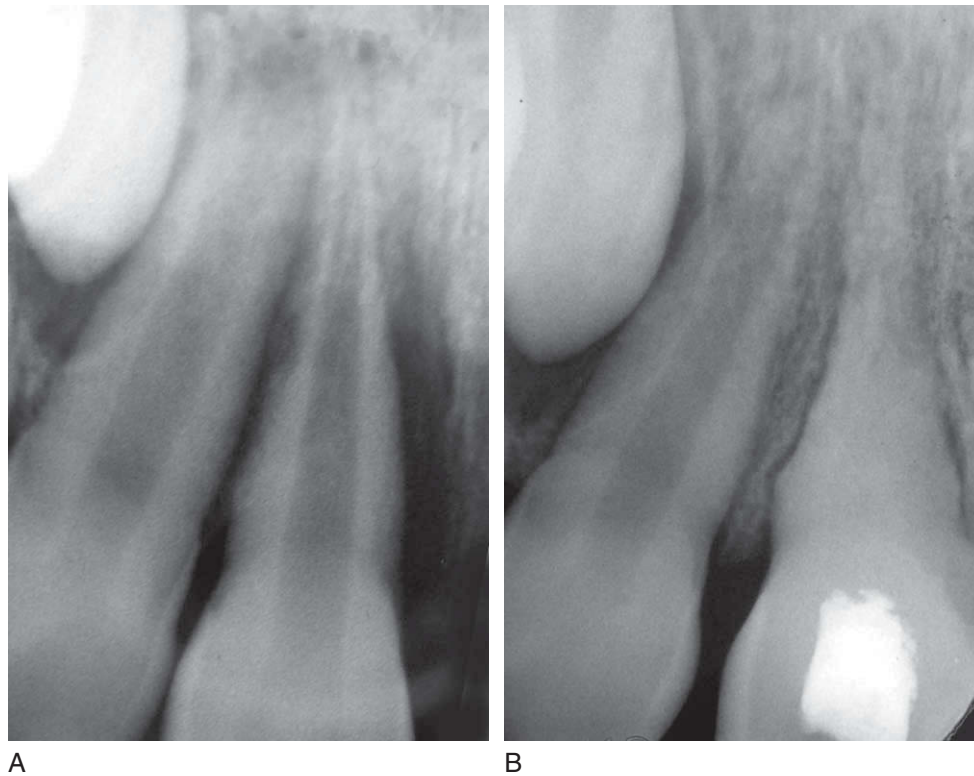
A, Radiograph showing an advanced stage of external IRR. The tooth had been avulsed and replanted. Patient was noncompliant and endodontic treatment was started too late, after much of the root had already resorbed. B, Radiograph of the same tooth after being successfully treated with long-term calcium hydroxide therapy. The root surface remains irregular; however, the PDL space has reconstituted itself and presents a normal width that closely follows the root contour irregularities.
